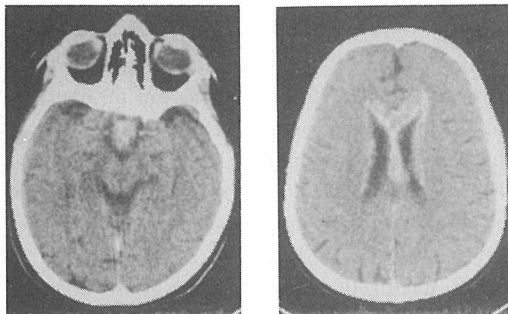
CT scans of Case No. 1; 55 months after therapy, when relapse was confirmed both biochemically and radiologically.
